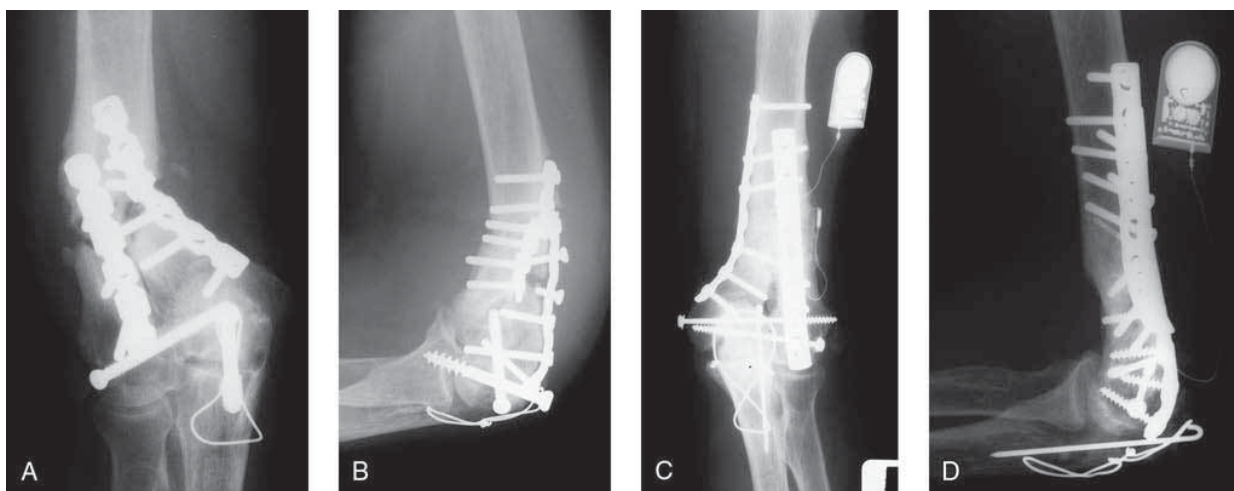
A, AP radiograph demonstrating a nonunion in a 53-year-old man who had sustained a fracture of the distal part of the humerus and had been treated with open reduction and internal fixation at another hospital 5 months previously. The patient reported pain with any motion of the arm and elbow, and the fracture site was tender to palpation and manual stress. B, Lateral radiograph of the elbow before the revision surgery. C, Revision fixation was performed with removal of hardware, bicolumnar plate fixation with longer plates to achieve better fixation on the proximal fragment, and the use of lag screws distally. A bone graft and an implantable bone stimulator were inserted. D, Lateral radiograph demonstrating healing after the revision.
